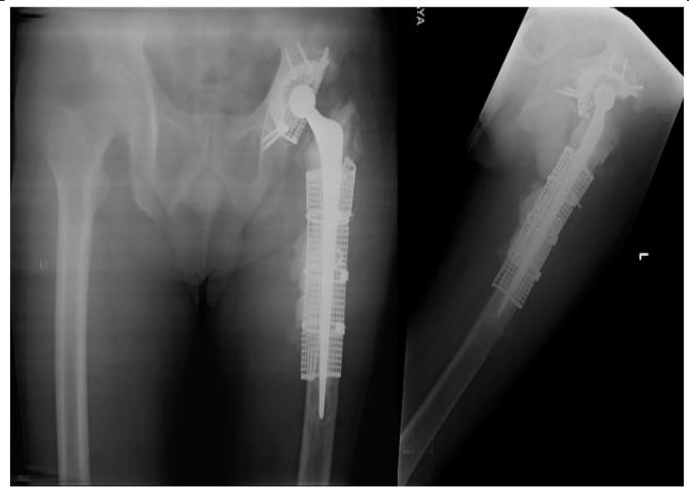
14 month's postoperative radiographs of revision left THA showing antero-posterior and lateral views
